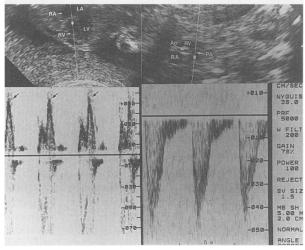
A pulsed Doppler evaluation of the atrioventricular (left) and semilunar (right) valves. Left, The top portion shows a 4-chamber view with the sample volume (box) below the tricuspid valve in the right ventricle (RV). The spectral display (bottom) shows a normal Doppler signal. The signal is biphasic with a large a wave (arrows) due to atrial contraction preceded by a smaller v wave due to rapid filling. The mirror image below the baseline is an artifact. Right, Pulmonary artery (PA) evaluation is done from the short axis, which also shows the aorta (Ao), right atrium (RA), and right ventricle (RV). The sample volume (box) is always distal to the valve and here is in the main pulmonary artery. The spectral display shows a classic arterial Doppler signal-pulsatile flow with a small amount of diastolic flow (from Schmidt and Silverman<sup>48</sup>).
